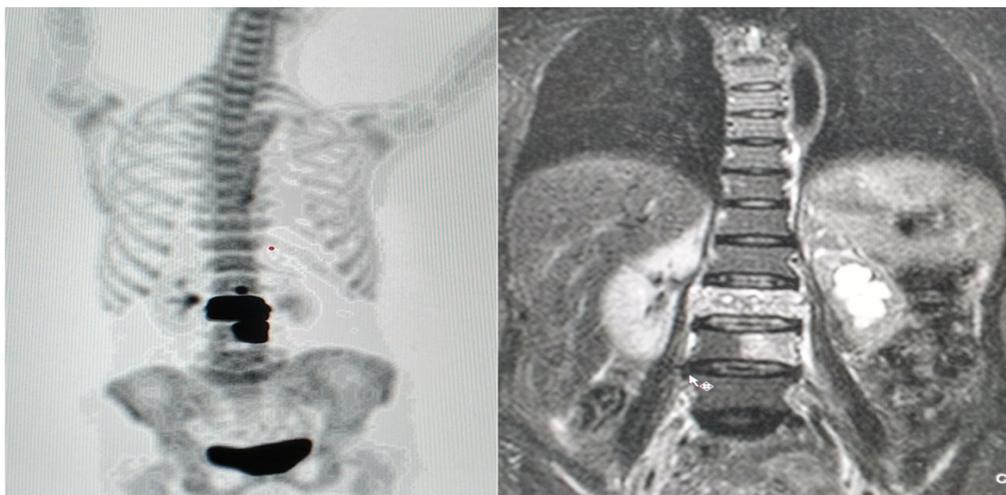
62 year old patient with CA prostate. PET scan showing increased uptake in L1, L2 and L3 vertebra. MRI STIR sequence of the same patient shows a hyper intensity in the L2 and L3 vertebra. Note the left sided hydronephrosis
